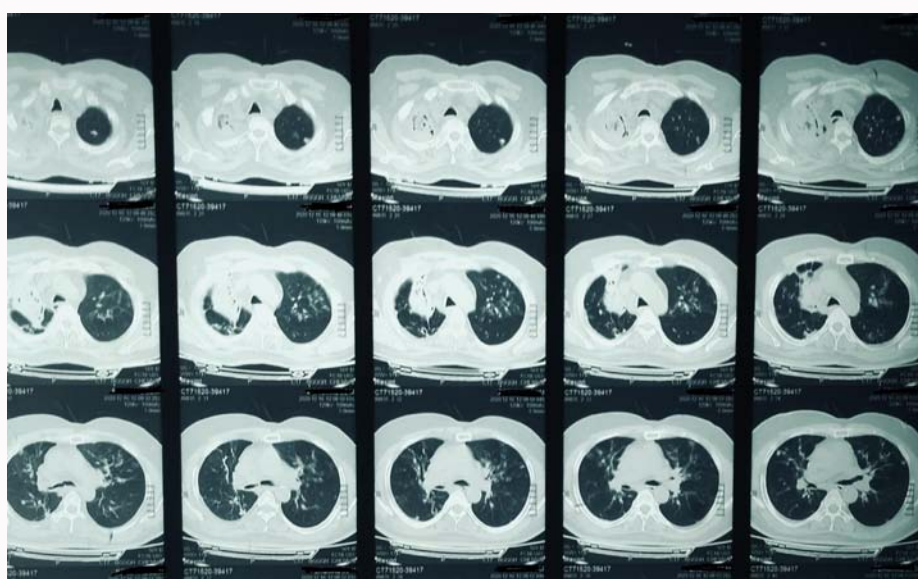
CT chest-aspergilloma in right upper lobe, PTB sequela changes.
